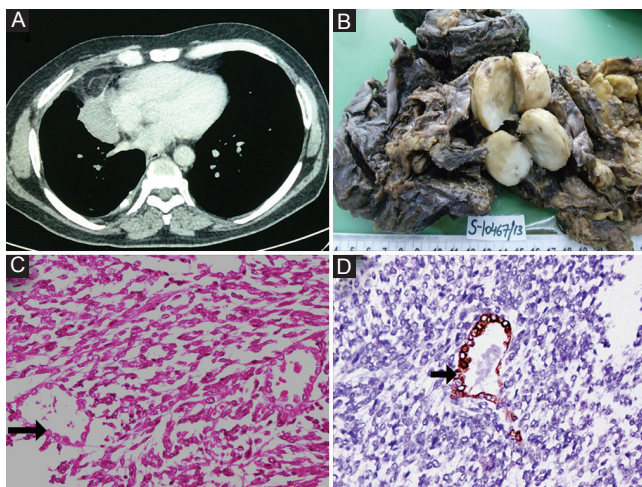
(A) Synovial sarcoma; contrast-enhanced computed tomography of the chest showing well-defined soft-tissue density lesion along vascular structures and right border of heart in anterior mediastinum, with right pleural thickening and calcification. (B) Grossly, the mass was adherent to the lung and was grey-white, fleshy on cut surface. (C) Tumour was composed predominantly of fascicles of monotonous spindle-shaped cells with stray small glandular structures (arrow) (H & E, ×200). (D) Epithelial elements are highlighted with cytokeratin (arrow) (IHC, ×200).
